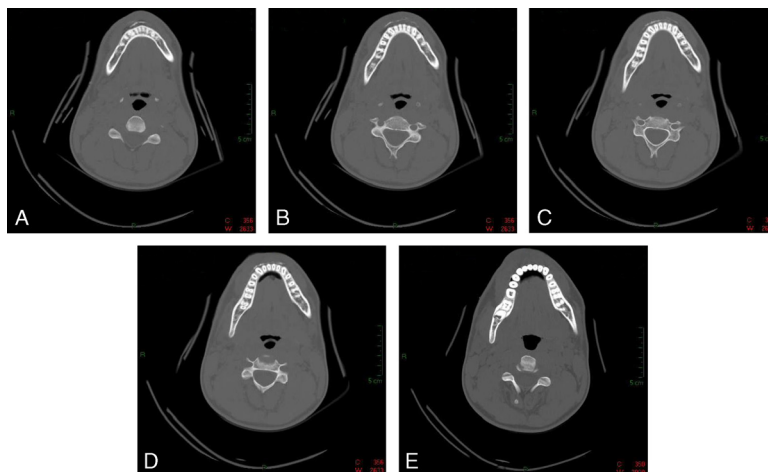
A to E, Computed tomographic scan sequence showing a peculiar hyperdense image resembling a vestibular cortical fracture of the mandibular body.
